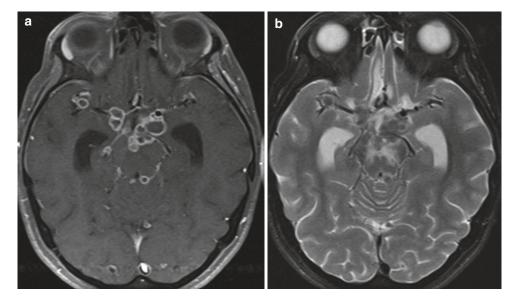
MRI of a 34-year-old female patient, who presented with headache and epileptic seizure, demonstrates the presence of tuberculous meningitis (TBM) affecting
